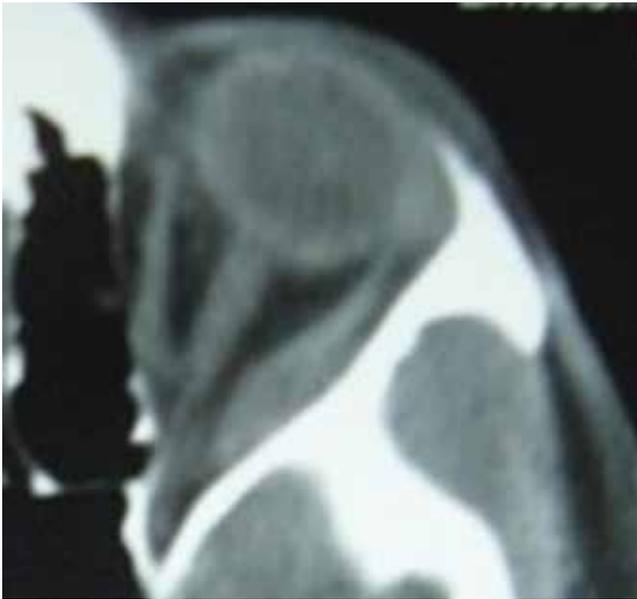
CT scan in axial view showing bulky left lateral rectus muscle.
